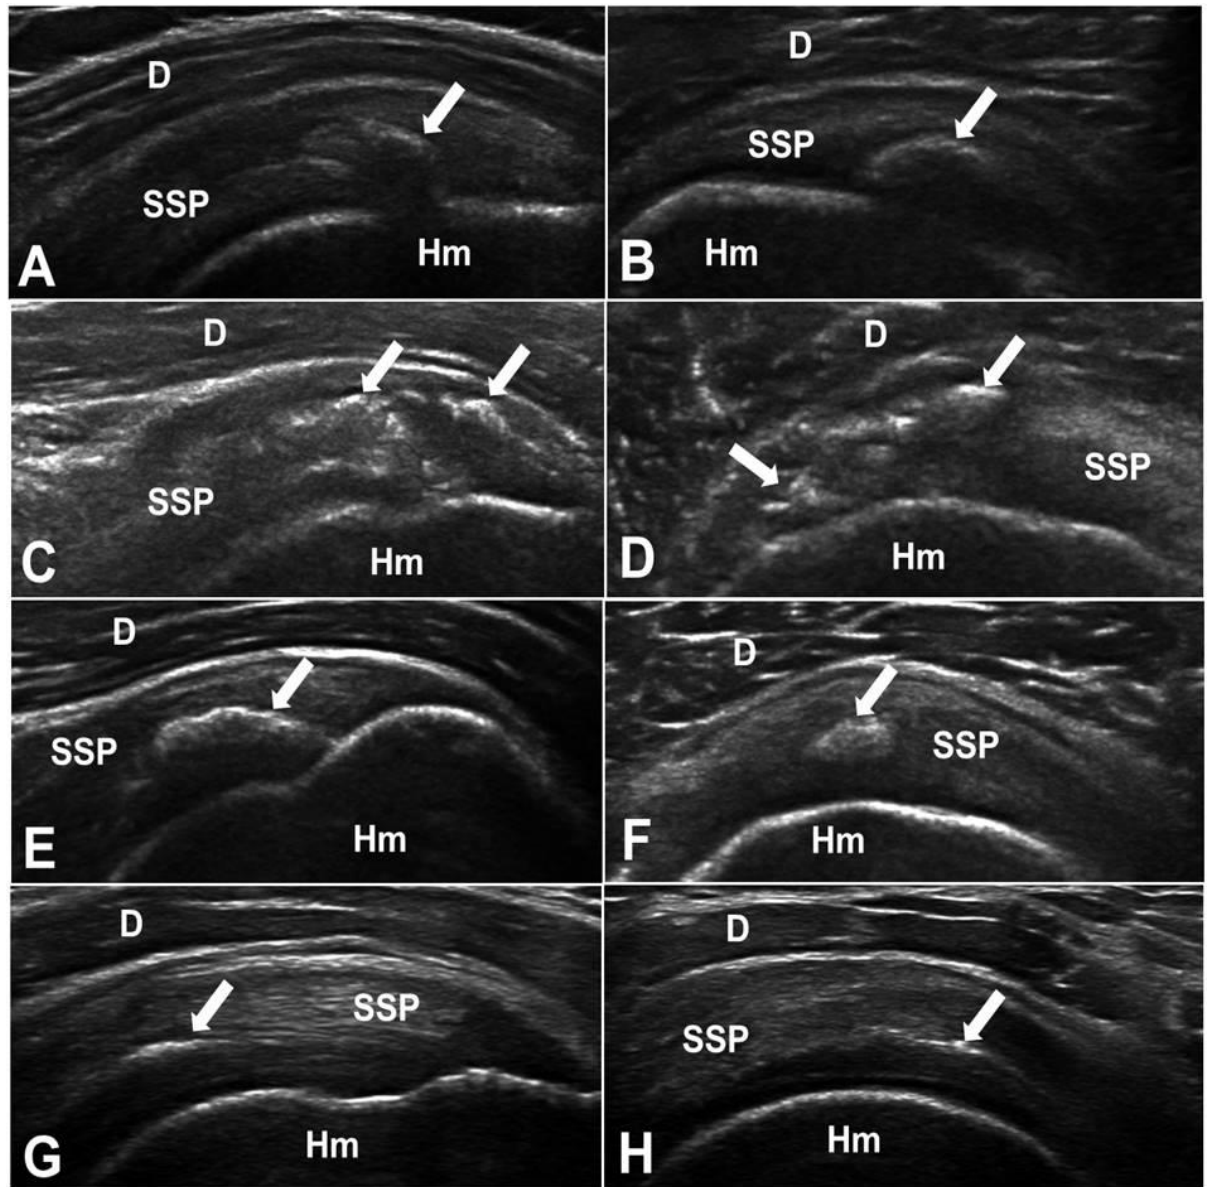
Morphology of calcification on longitudinal and transverse ultrasound imaging. (A, B) arc-shaped type (C, D) fragmented type, (E, F) nodular type, (G,H) linear type; D, deltoid muscle; SSP, supraspinatus muscle; Hm, humeral head; arrow, calcification.
